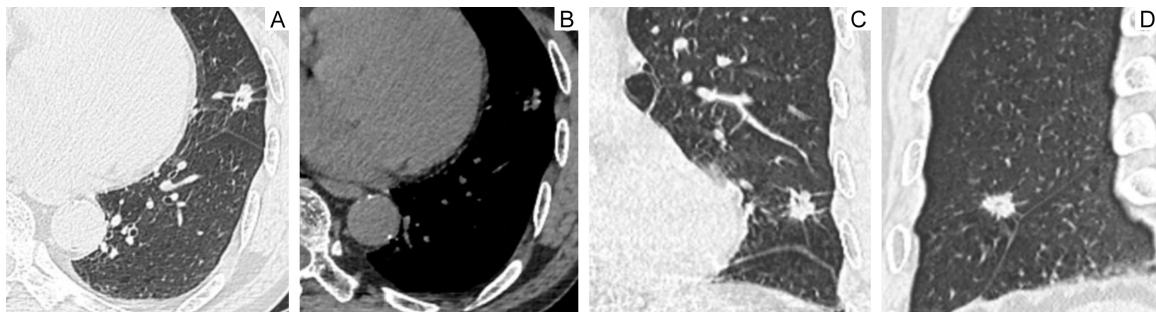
A 66-year male patient of low-grade LAC with IPF from the test set. (A, B) Axial chest CT images show a soft tissue nodule located in the upper lobe of the left lung. (C) Coronal and (D) sagittal CT show the tumor with lobulation, speculation, bubble lucency, and pleural indentation. Notes: LAC, high-grade lung adenocarcinoma; IPF, idiopathic pulmonary fibrosis.
